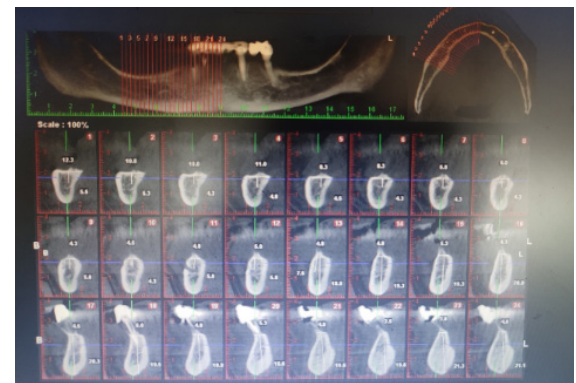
CBCT of the patient and severe bone loss.
